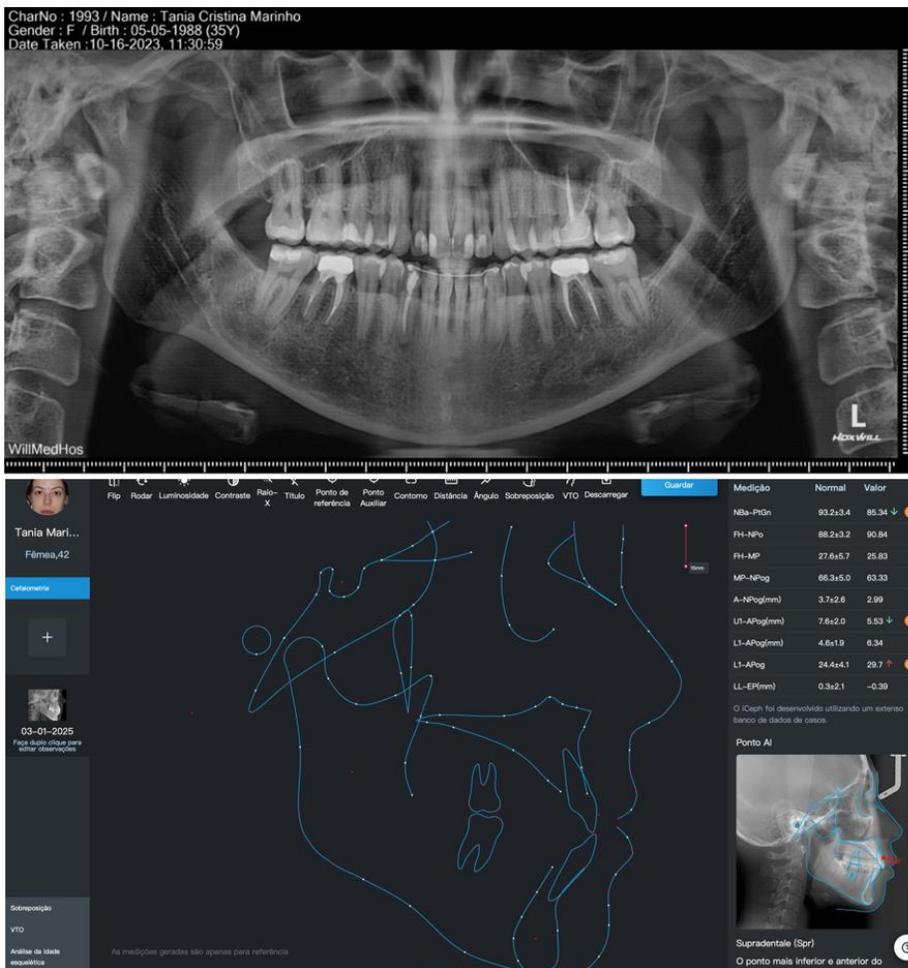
X-ray pictures.
